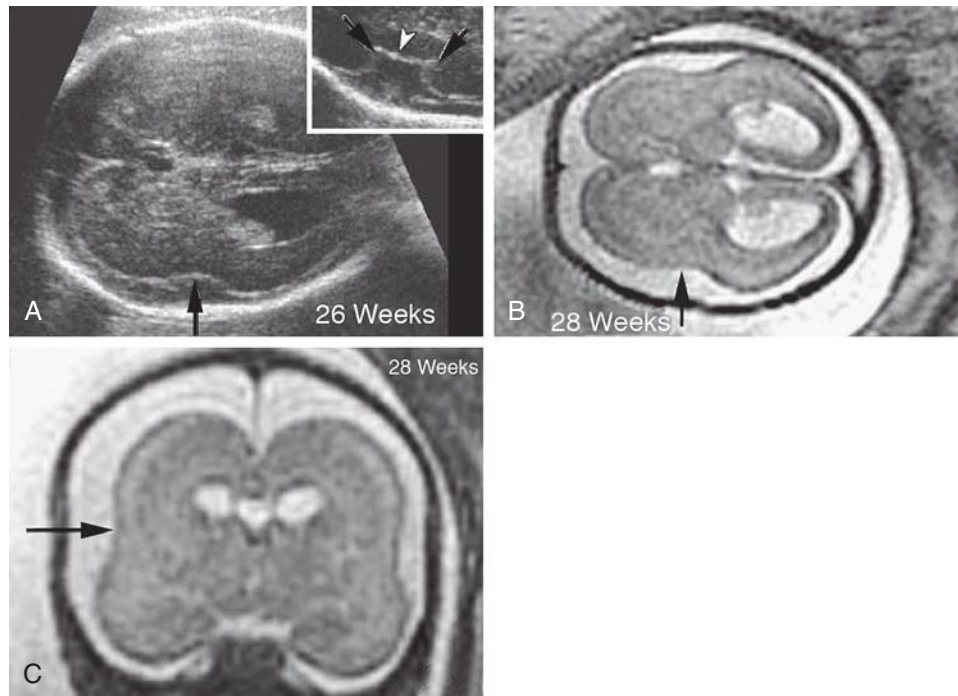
Abnormal sylvian fissure/insula at 26 weeks. A, Axial ultrasound image at 26 weeks in a fetus with lissencephaly associated with Miller-Dieker syndrome shows a shallow, flat sylvian fissure/insula (arrow) with absence of angularity at the insular margins. Inset shows the expected appearance of the sylvian fissure/insula in a 26-week normal fetus. Infolding of the operculum should be seen with acute angles (black arrows in inset) at the margins of the insula (white arrowhead in inset) at 24.5 weeks' gestation. Axial (B) and coronal (C) T2-weighted magnetic resonance images at 28 weeks in the same fetus with Miller-Dieker syndrome showing a shallow sylvian fissure (arrow). The brain has an hourglass or figure-of-eight appearance on the axial image. Also note the agyria, large subarachnoid space, and mildly dilated occipital horns. (From Fong KW, Ghai S, Toi A, et al: Prenatal ultrasound findings of lissencephaly associated with Miller-Dieker syndrome and comparison with pre- and postnatal magnetic resonance imaging. *Ultrasound Obstet Gynecol* 24:716, 2004, used with permission.)
